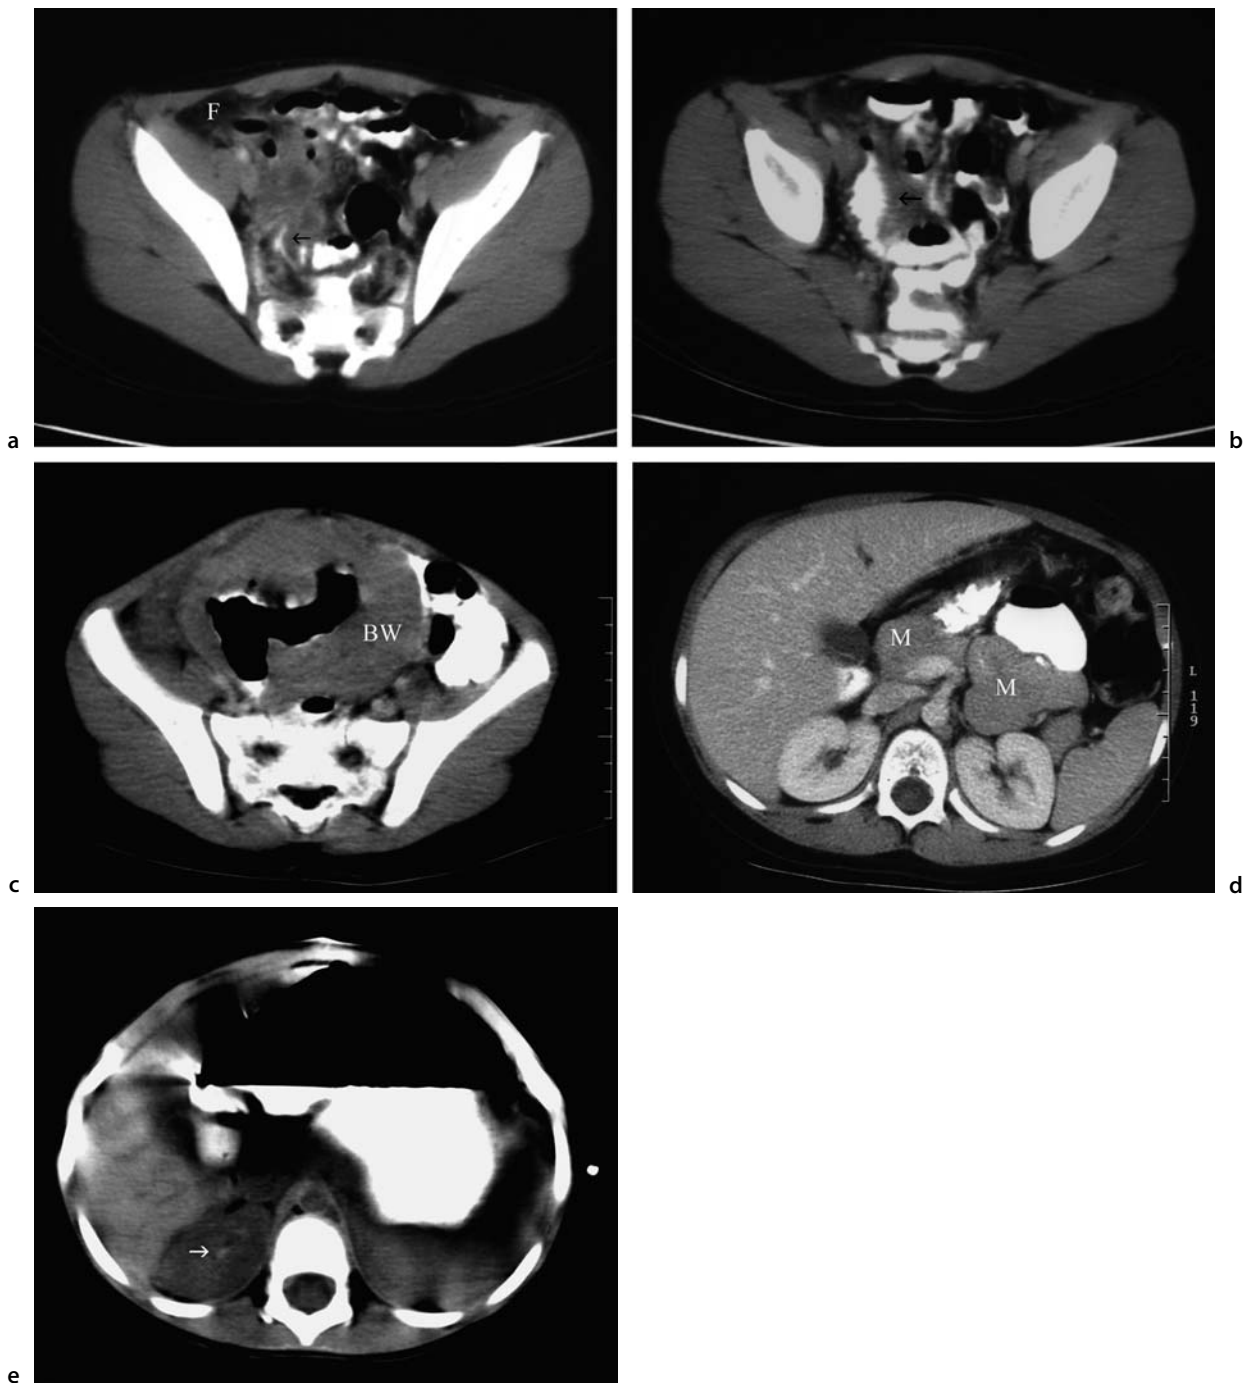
Abnormal CT scans
